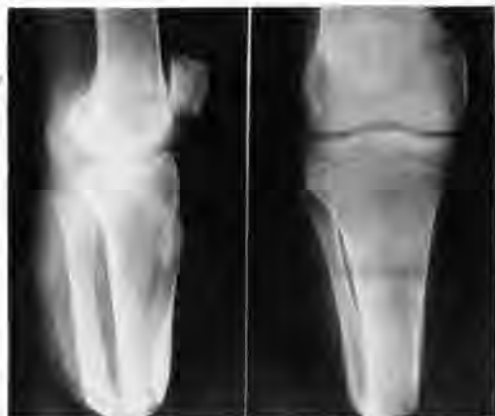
Radiographs (lateral projection on the left, antero-posterior on the right) show established bony bridge between the tibia and fibula some three years after operation.
